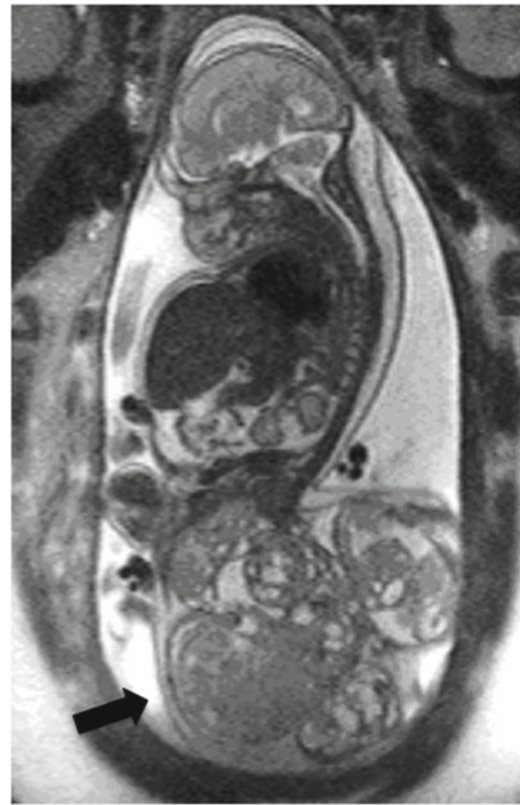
Ultrafast fetal MRI of fetus with SCT. 22-week gestation fetus with large predominantly solid type I SCT (arrow)
